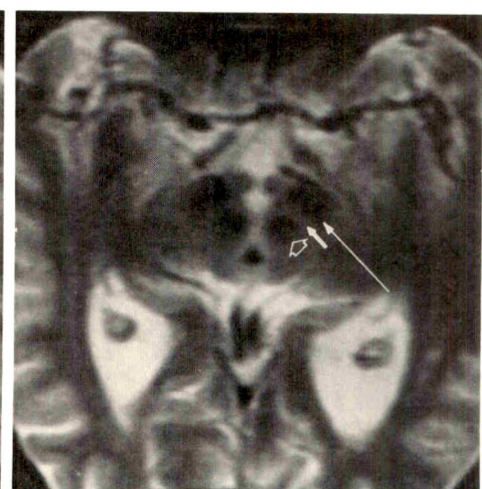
MR image (2500/80) of 60-year-old woman scanned for unrelated disorder (control subject). Scanning plane is 0–20° positive to inferior orbitomeatal line. Pars compacta of substantia nigra (short solid arrow) is the relatively hyperintense band between hypointense pars reticulata (long solid arrow) of substantia nigra and hypointense red nucleus (open arrow).
